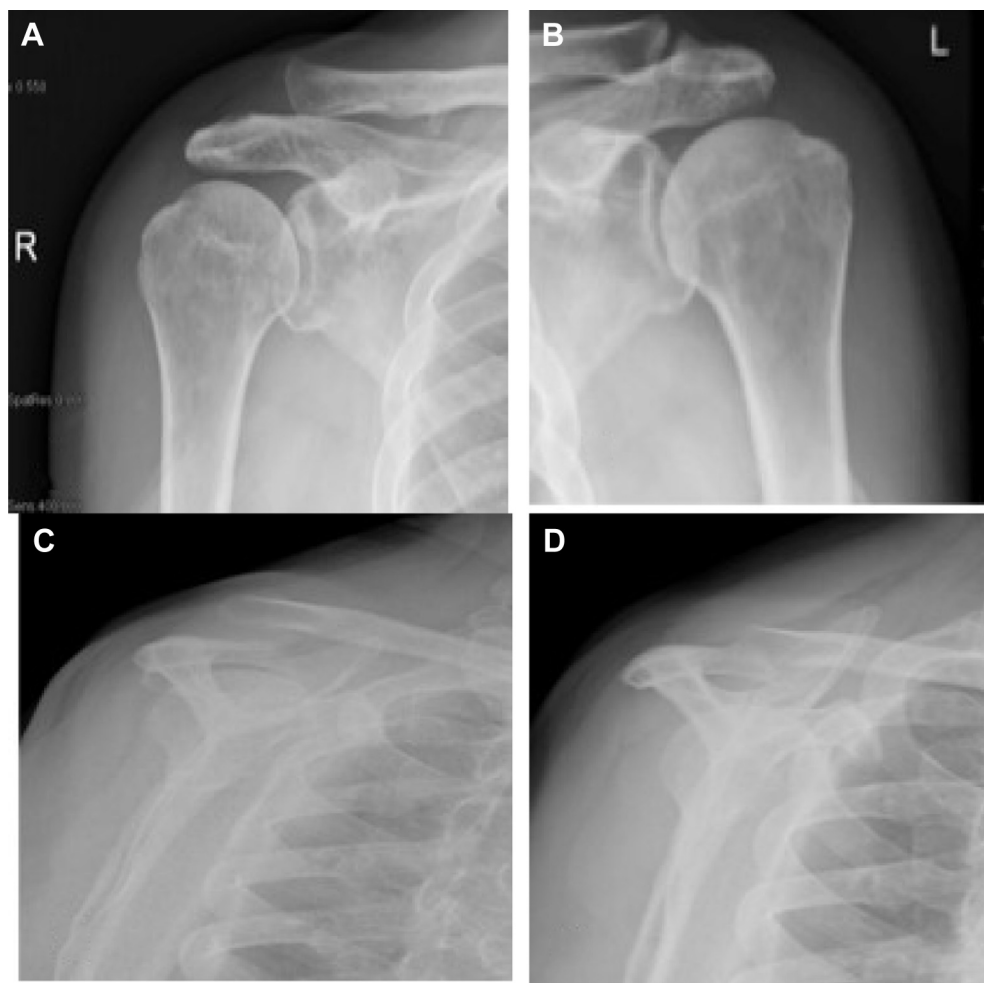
Case number 8. Preoperative stress radiographs of a chronic acromioclavicular joint separation demonstrated in both planes (A: Zanca view; C: Alexander view) compared with the healthy side (B: Zanca view; D: Alexander view). R, right; L, left.
